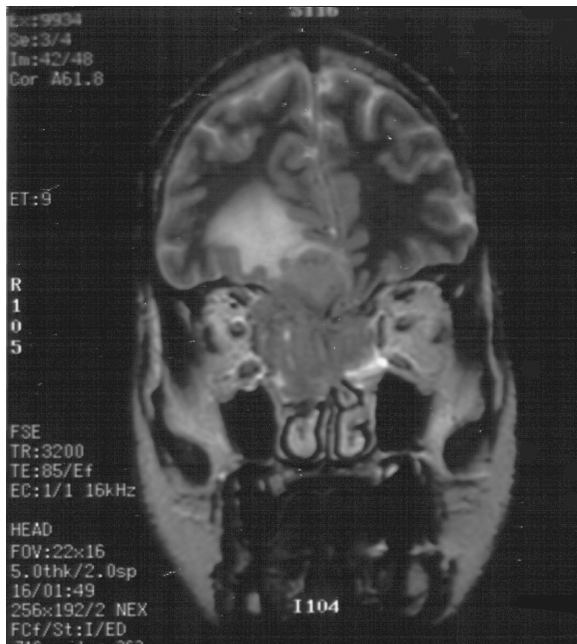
Same patient as Figs 13 and 14. Coronal T2W MRI demonstrating the slightly hypointense olfactory neuroblastoma extending both intra-orbitally and intracranially with extensive edema in the right frontal lobe.
